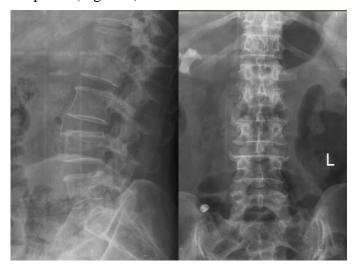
LL (left) and PA (right) radiographies of the lumbar spine
